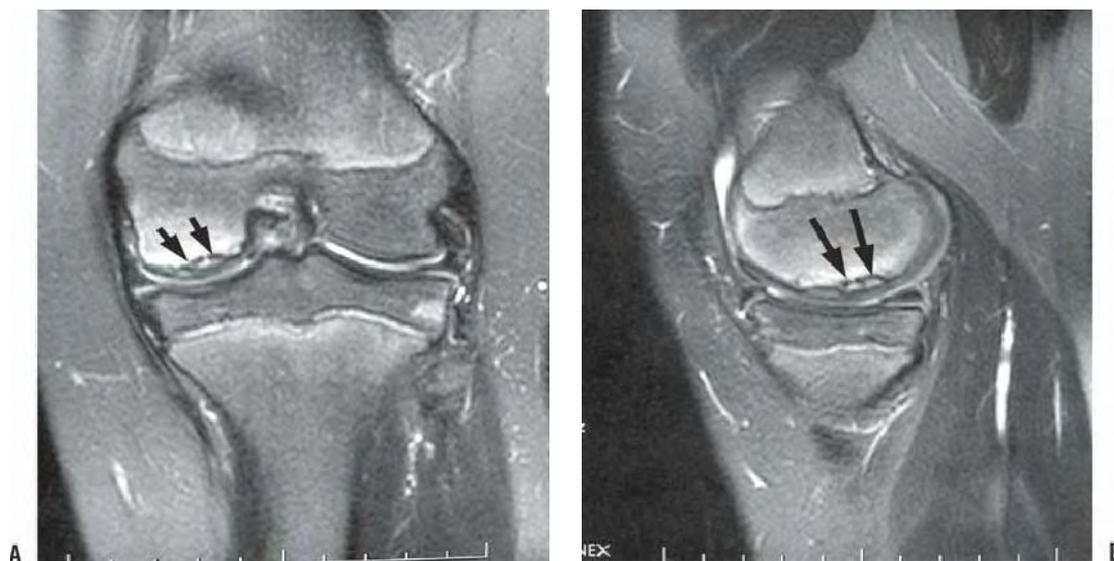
A: MRI of a knee demonstrating OCD lesion (*black arrows*) in the classical location (lateral aspect of medial femoral condyle). The lesion appears to be stable, with an intact articular surface. B: Lateral image of same knee (*black arrows* outline lesion).
